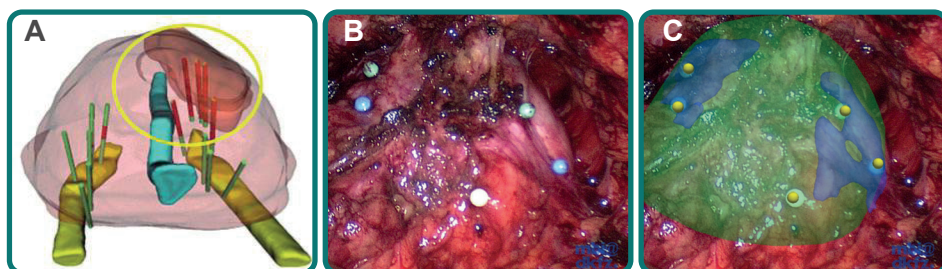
VR and AR technologies during prostatectomy. (a) A TRUS/MRI-based VR model to be used in parallel to the laparoscopic view [36]. Different structures are shown: prostate (pink), ureter (blue), neurovascular bundles (yellow), biopsy-proven tumor lesion (red), and tumor biopsy cores (green (tumor negative) and red (tumor positive) cylinders). (b) After placement of intraabdominal fiducials (colored and echogenic pins in the prostate surface), (c) TRUS-based AR overlay of the prostate (green) and neurovascular bundles (blue) could be shown during (RA)LP [37].
